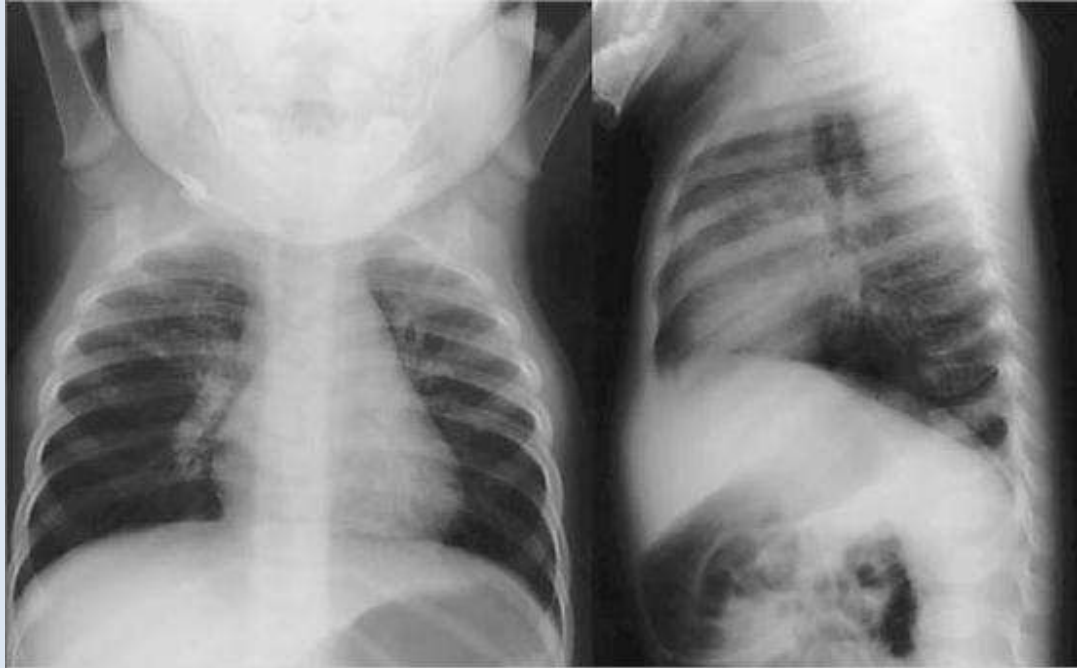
Chest radiograph obtained in a six-month-old Infant with human metapneumovirus bronchiolitis showing hyperinflation and diffuse perihilar infiltrates.
